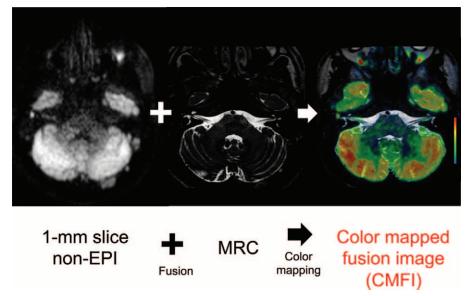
CMFI processing. We combined a 1-mm slice non-EPI DWI with MRC. We also performed color mapping to enhance the visualization of the cholesteatoma. MRC indicates MR cisternography.
